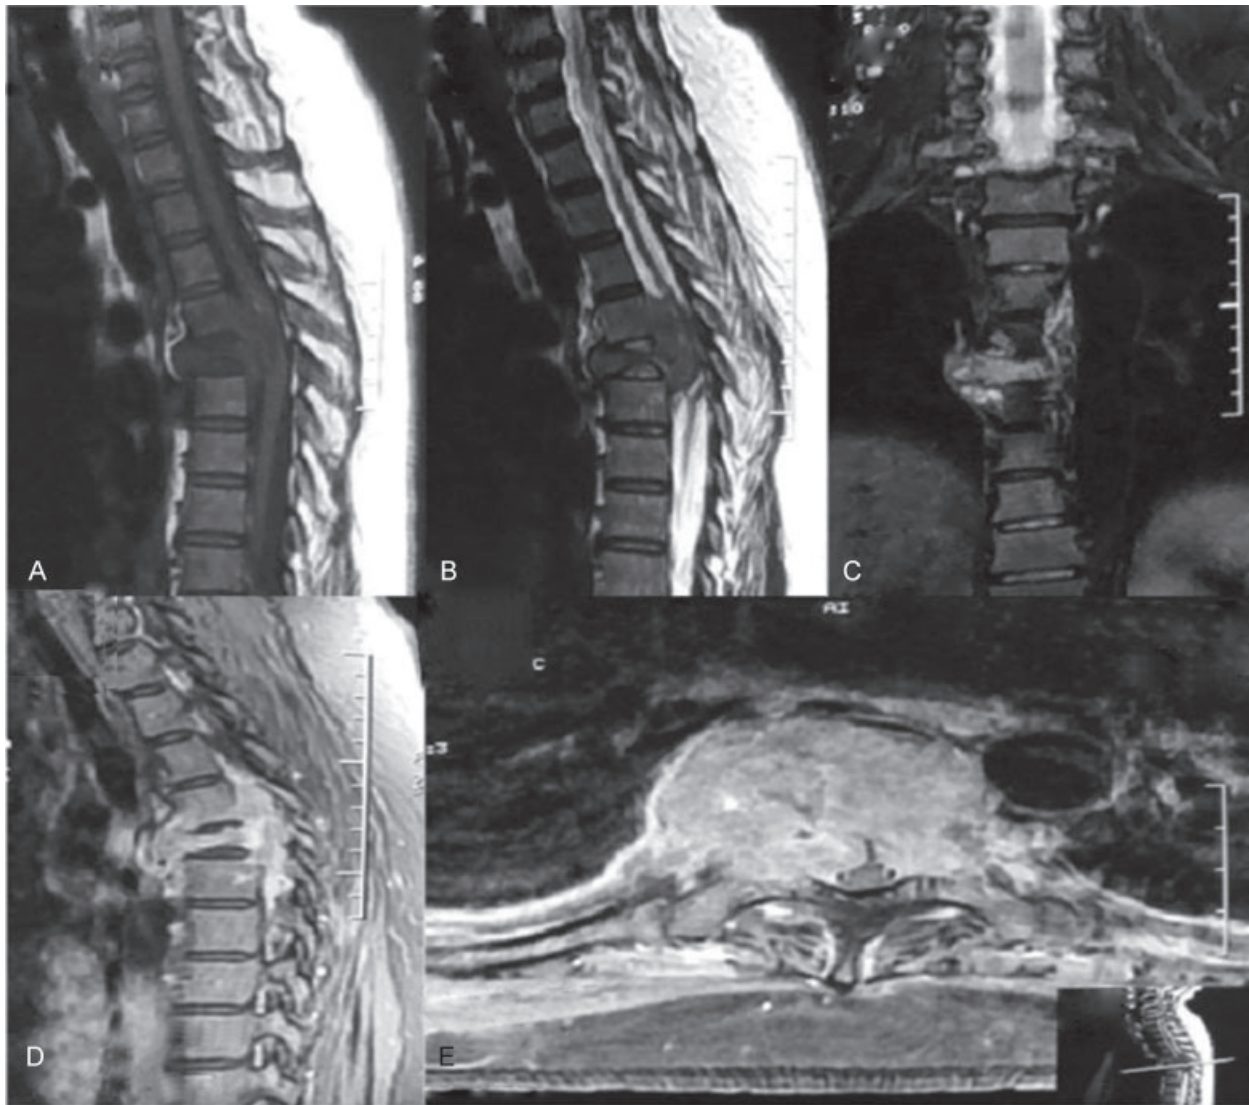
Magnetic resonance images: (A) T1 sagittal image, (B, C) T2 sagittal and coronal image, and (D, E) contrast sagittal and axial image.
